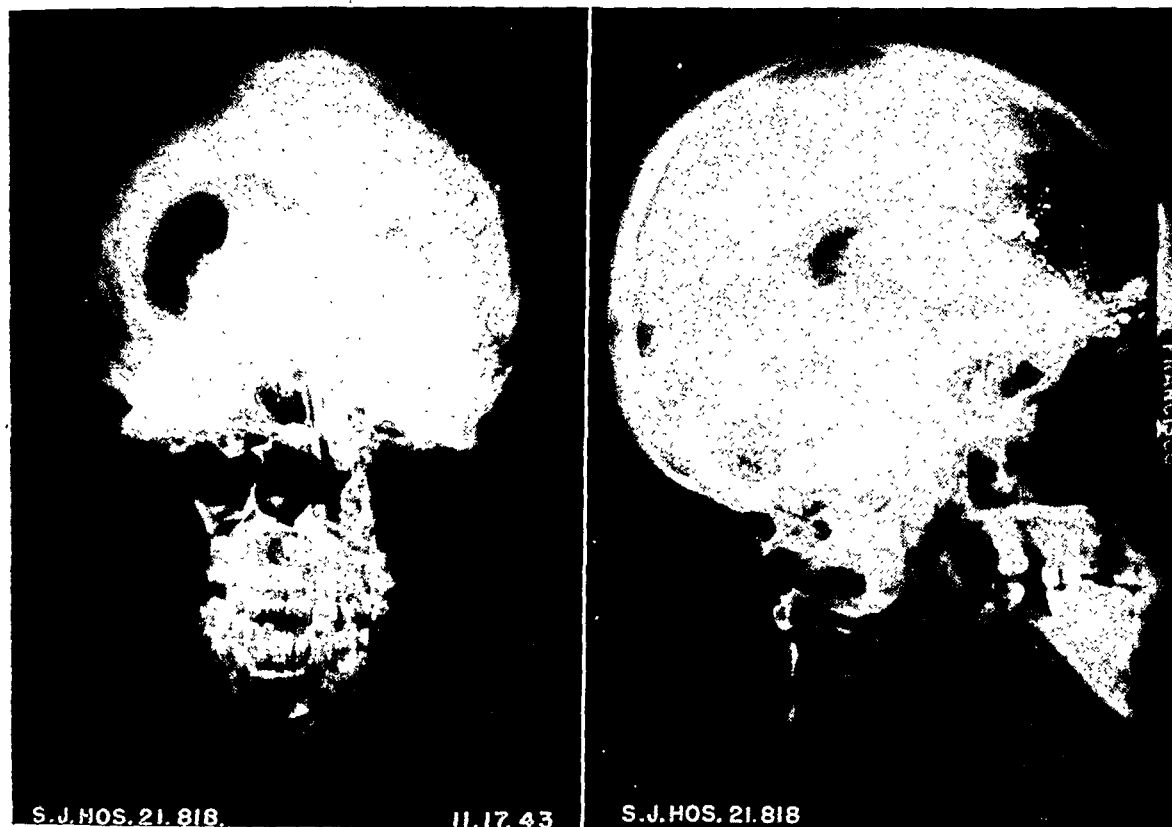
Roentgenograms made Nov. 17, 1943, nine weeks after injury, showing air in the ventricles, and subdural air in the right frontal region.
